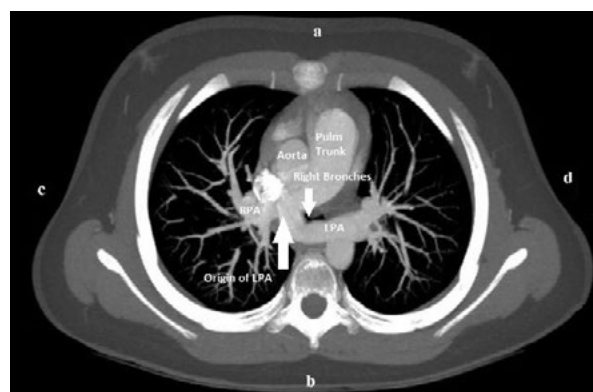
Pulmonary artery sling CT scan – the left pulmonary artery (LPA) originates from the right pulmonary artery (RPA) and lies posteriorly to the trachea creating a vascular sling
